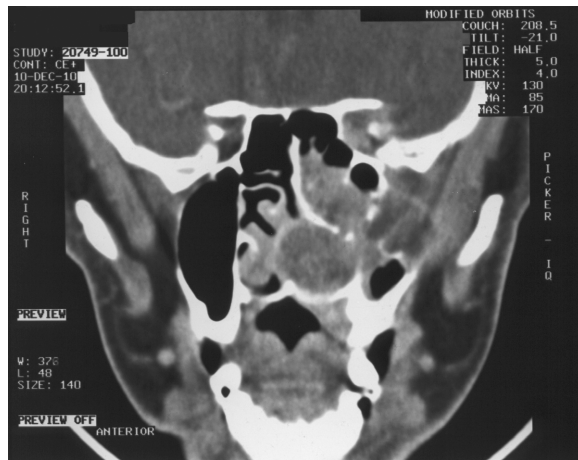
Coronal CT post-contrast same patient as Fig. 5 with ACC. Demonstrating tumour throughout the left nasal cavity with bony destruction of the left maxillary sinus, loss of fat in the left infratemporal fossa and extension in the left orbital apex along the V2 division.
